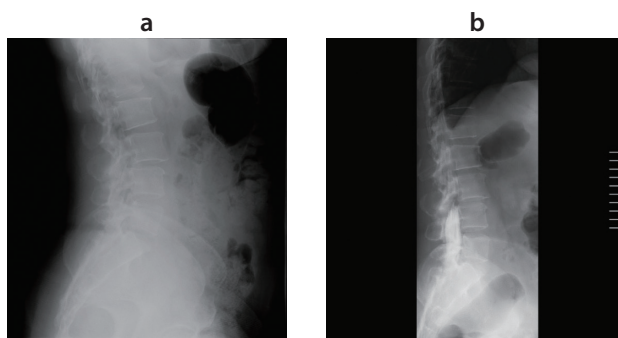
Comparison of images of the same patient obtained by general radiography and by Zexira i9
